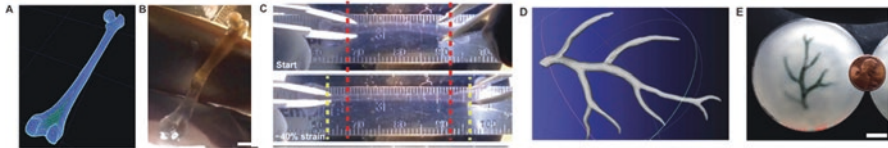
Printing of biologically relevant structures using freeform reversible embedding of suspended hydrogels (FRESH) printing technique. (a) A model of a human femur from 3D CT imaging data is scaled down and processed into machine code for FRESH printing. (b) The femur model printed in alginate. (c) Response of FRESH printed femur to mechanical stress. (d) A model of a section of a human right coronary arterial tree from 3D MRI is processed at full scale into machine code for FRESH printing. (e) Arterial tree printed in a gelatin slurry. (Reprinted with permission from [44])
